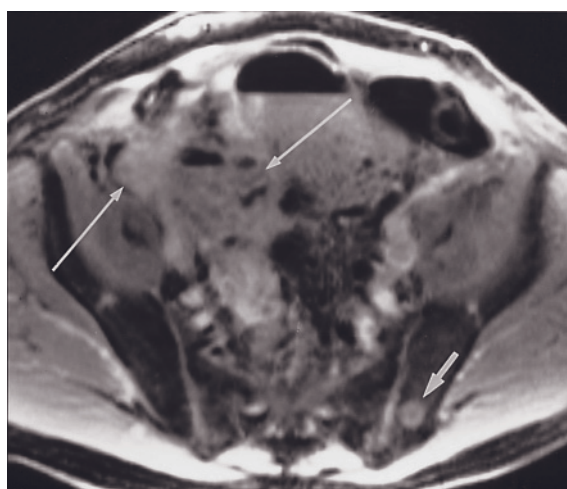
Metastatic yolk sac tumor. Transverse 512-resolution T2-weighted echo-train spin-echo image in a patient with metastatic yolk sac tumor. Ovarian yolk sac tumors spread to the peritoneum (solid arrows), omentum, and retroperitoneal lymph nodes (open arrow).
